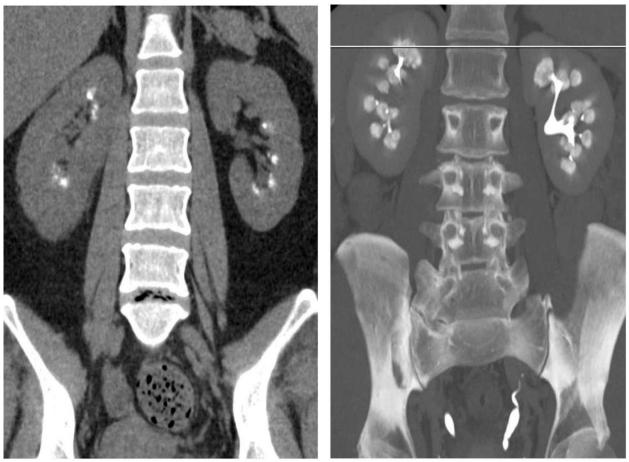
Medullary sponge kidney. Coronal noncontract computed tomography images showing amorphous and course pyramidal calcifications in both the kidneys. Postcontrast excretory phase maximum intensity projection images show a "paintbrush" like appearance to the renal calyces.
